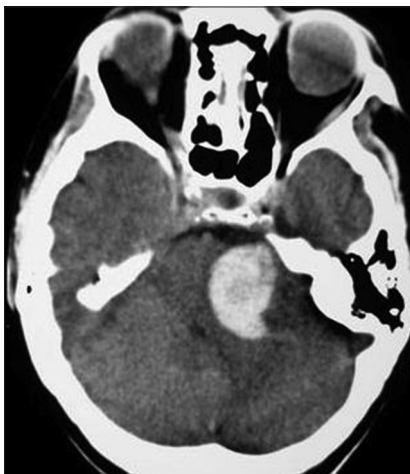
CT scans reveal an hyperintense lesion occupying the CPA cistern with compression of adjacent parenchyma
